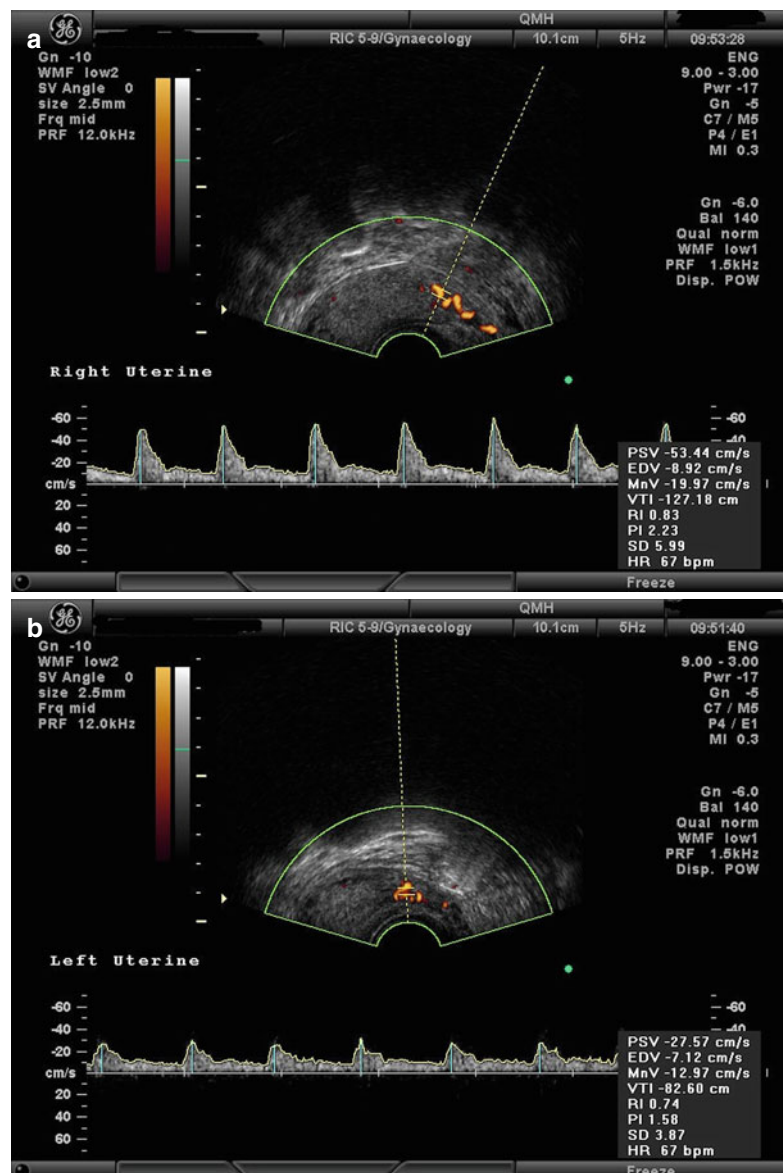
Right (a) and left (b) uterine blood flow measured by 2D Doppler ultrasound
